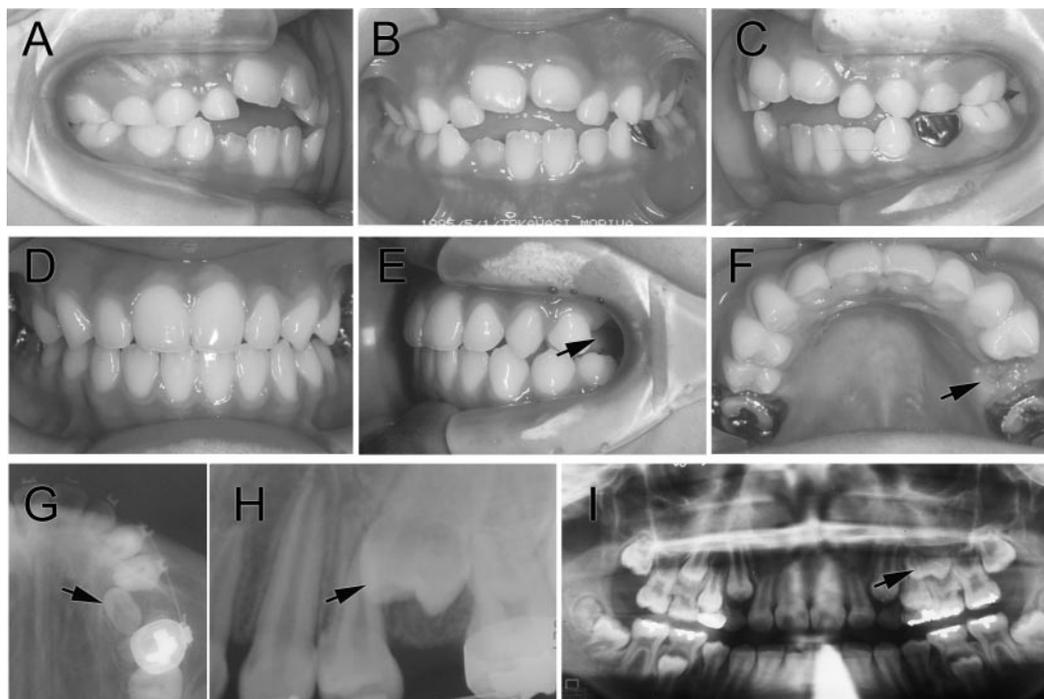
Case 1: (A,B) Oral photograph in first visit. (D-F) Oral photograph after first phase treatment. (G) Panoramic radiography. (H) Occlusal X-ray film. (I) Dental X-ray film. All single arrows indicate the impacted left second premolar.
